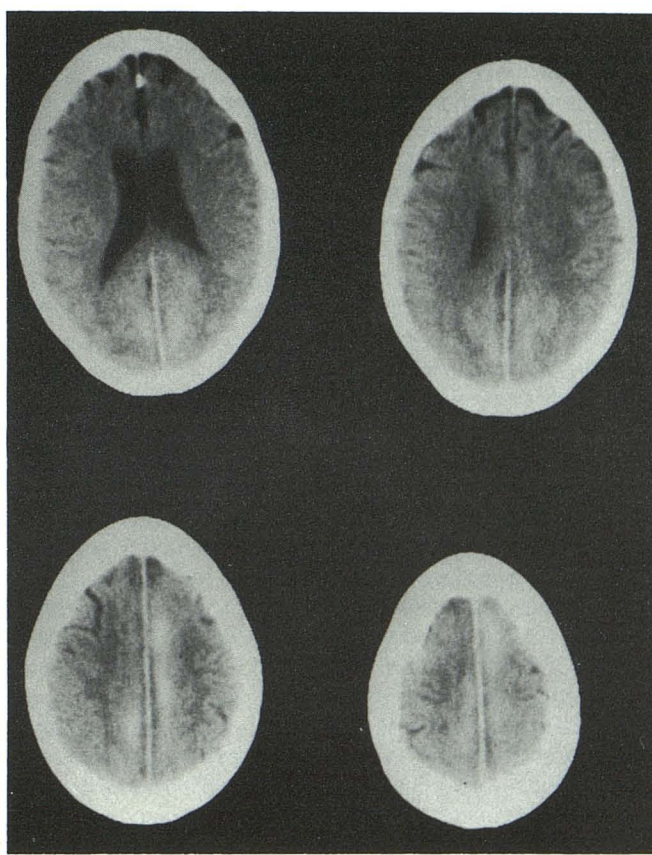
CT scans 2 weeks later show so-called "melting" resorption of bilateral interhemispheric subdural hematomas with some blood remaining in central areas.
